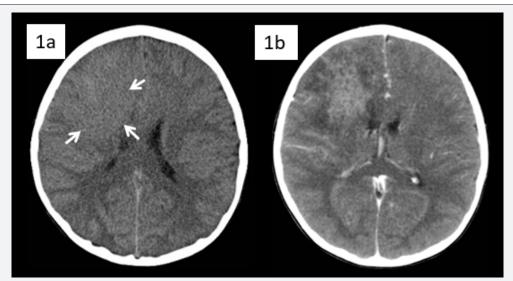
Head CT of a 4-year-old male with right frontal lobe mass.
